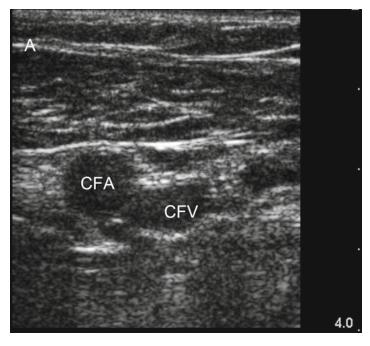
Femoral vein access. Ultrasound demonstrates that the common femoral vein (*CFV*) lies deep and medial to the common femoral artery (*CFA*) in most patients (a), but sometimes the vein may lie directly underneath the artery. Whilst palpating the artery with the left hand and maintaining gentle suction on the syringe with the right hand (b), the physician inserts the needle into the common femoral vein 1–3 cm inferior and medial to the common femoral artery (c)
